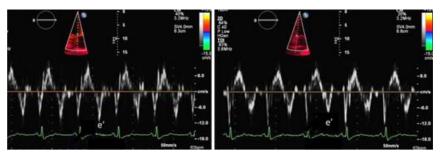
Doppler tissue imaging of medial (*left*) and lateral mitral annulus (*right*). The medial e' velocity (*arrow*) is 12 cm/sec, and the lateral e' velocity is lower at 8 cm/sec.
